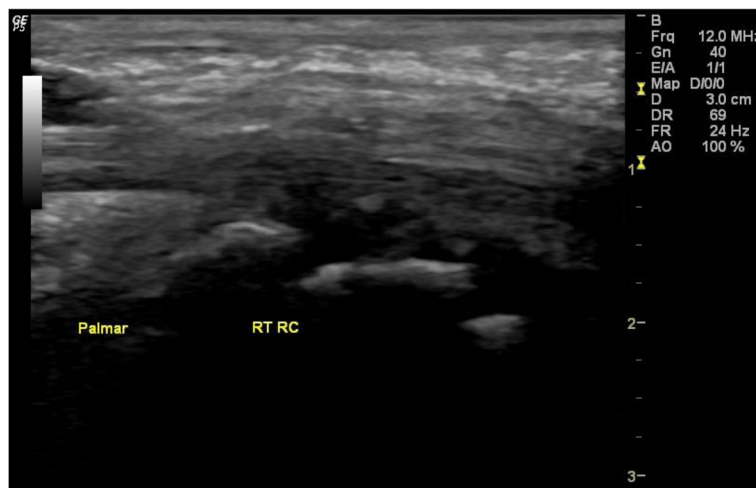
Ultrasound scan of a patient (4) with disease activity score (DAS28) = 5.67 showing longitudinal gray scale ultrasound scan of the right radiocarpal (RC) joint nondisplaceable, poorly compressible tissue occupying the joint space and distending the capsule
